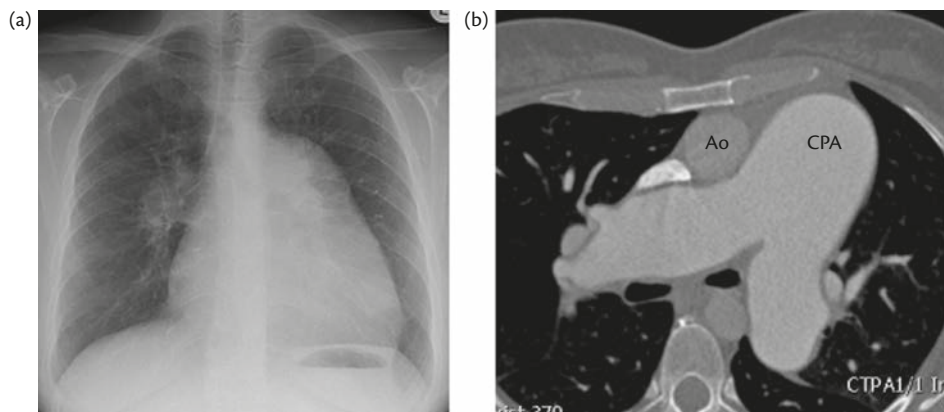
Chest radiograph and computed tomography scan (CT) in a patient with idiopathic PAH. (a) Plain chest radiograph in a patient with idiopathic PAH showing cardiomegaly and enlargement of the proximal pulmonary arteries. (b) Marked enlargement of the central pulmonary artery (CPA) diameter in relation to the adjacent aorta (Ao) in a CT pulmonary angiogram.
